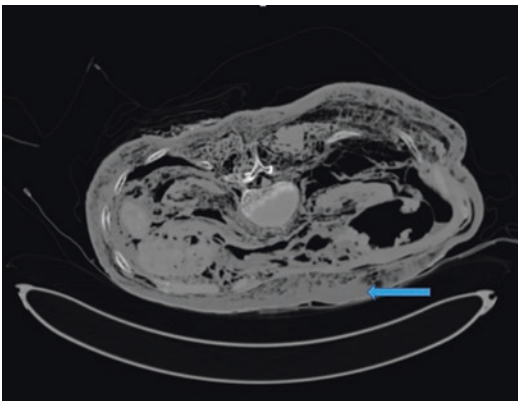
CT imaging of abdominal wall hypostasis (arrow) on a putrefactive corpse
